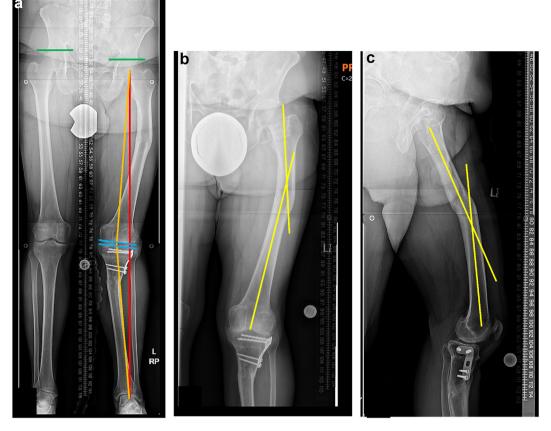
(a) Global deformity analysis with mechanical axis deviation (MAD) (red), mechanical tibiofemoral angle (orange), joint line convergence angle (blue), and leg length discrepancy (green). AP (b) and lateral (c) femur radiographs used to calculate segmental deformity angulation and translation.
